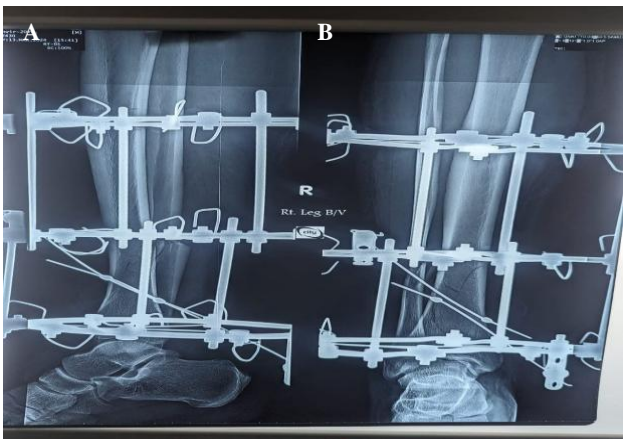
(A and B): Post-operative X-ray showing the application of the Ilizarov circular fixator.
